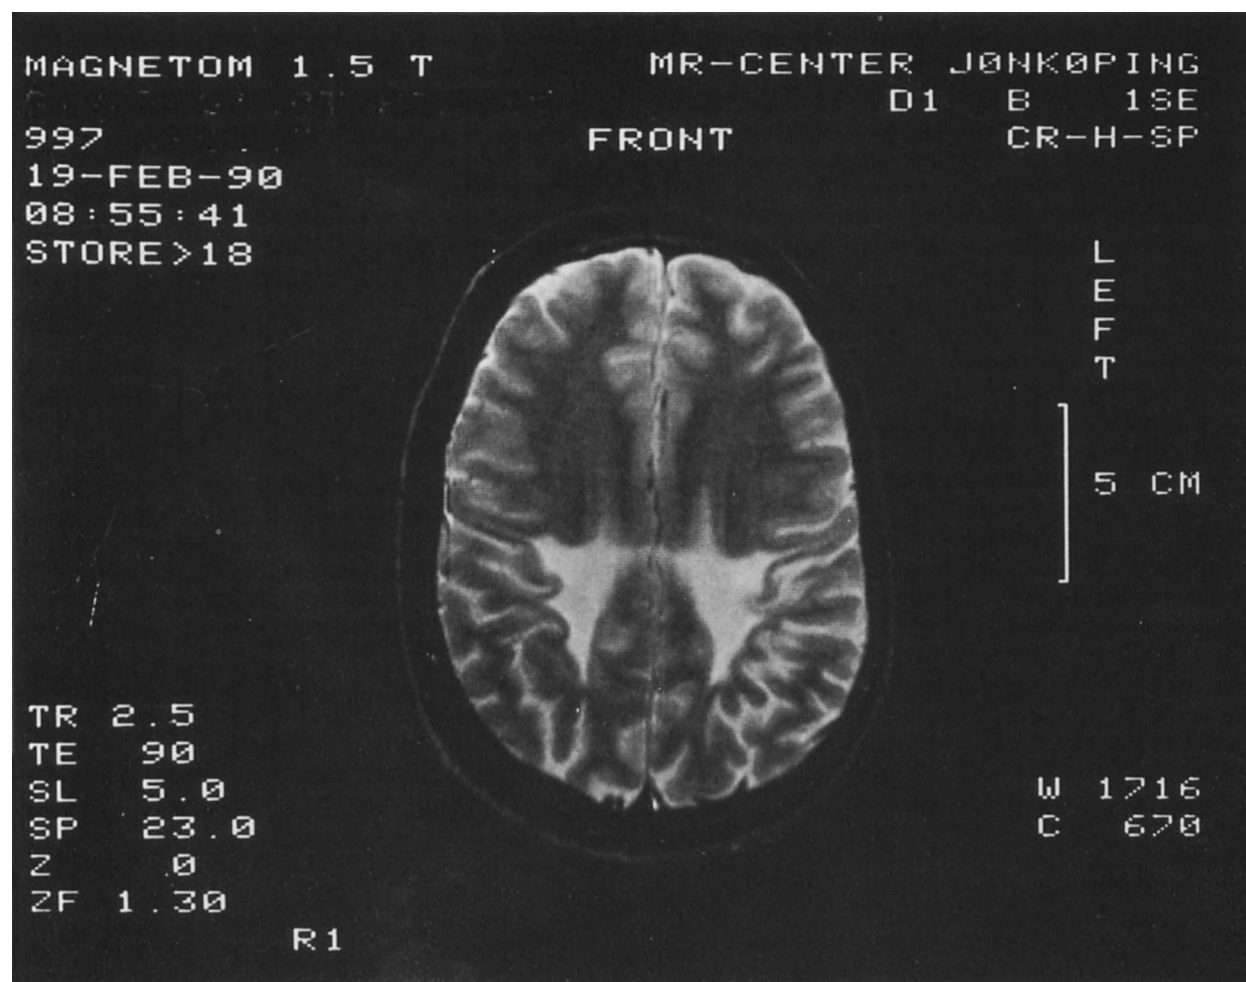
MRI of the brain at 21 years of age showing marked white matter lesions, particularly in the parietal, but also in the frontal and temporal areas.
